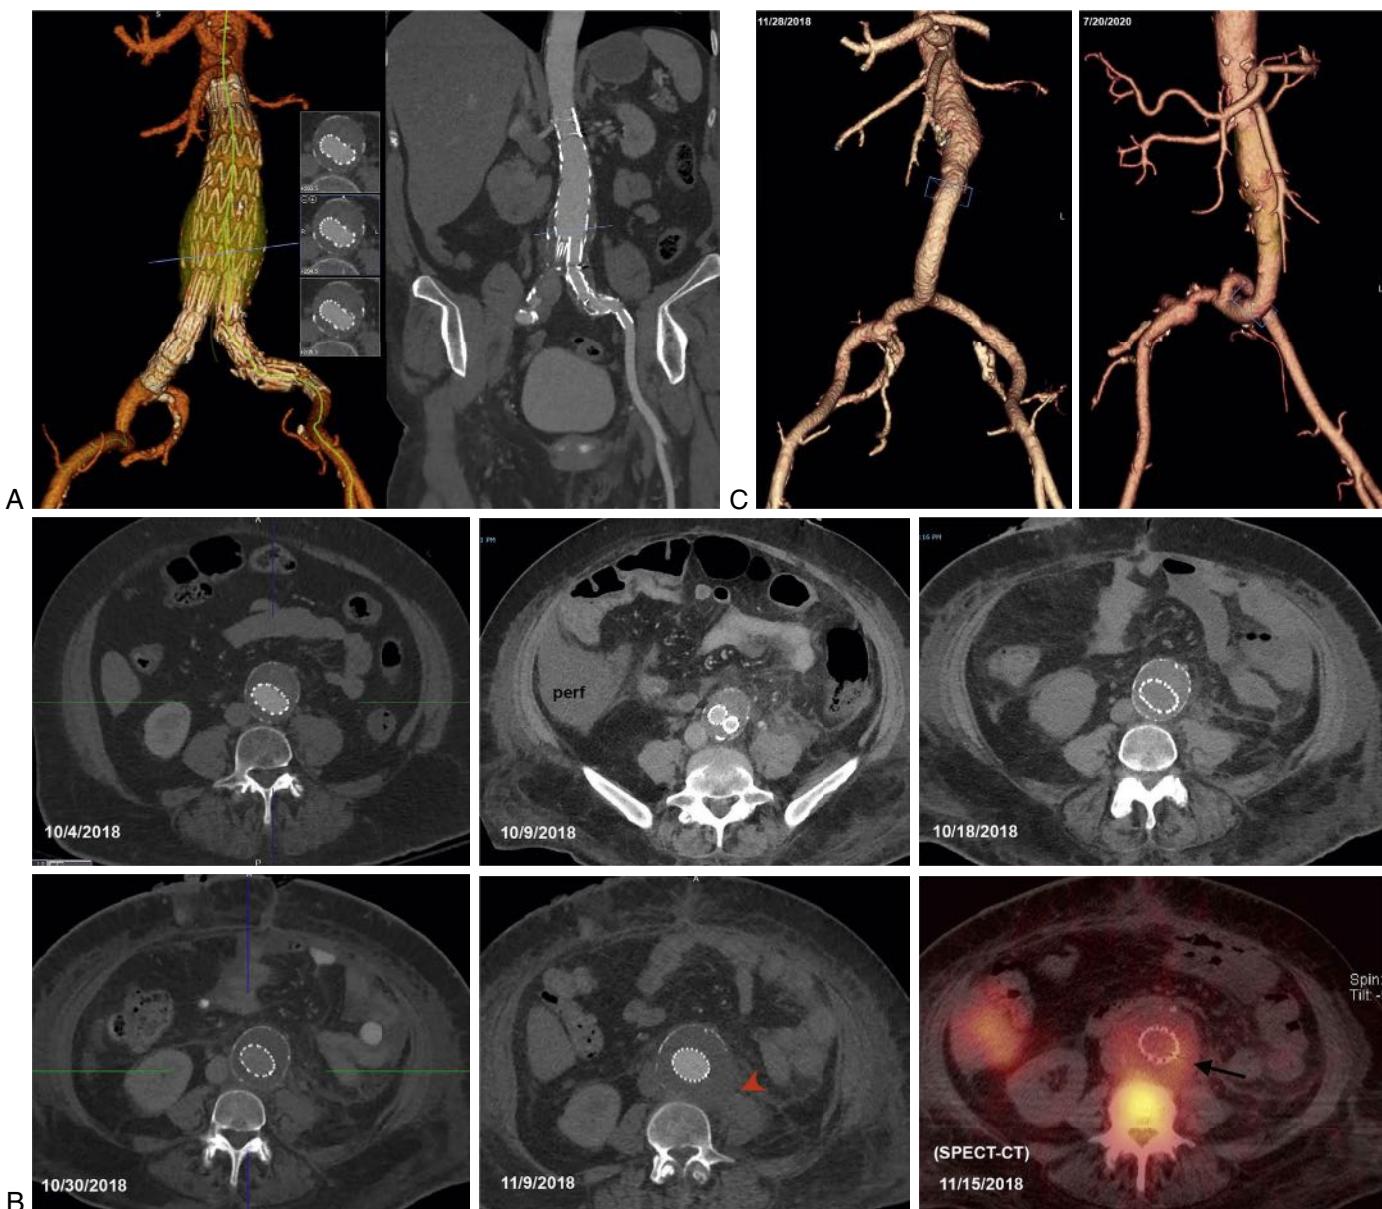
A 63-year-old female patient who underwent an EVAR for a 5.2-cm infrarenal AAA using a Zenith Flex device (Cook, Bloomington, IN). She had an ectatic left common iliac artery necessitating coverage of the hypogastric artery and extension into the external iliac artery. (A) CTA on postoperative day 1 after development of low abdominal pain. Endoscopic diagnosis of ischemic proctocolitis, initially managed conservatively until she developed perforation requiring hemicolectomy with colostomy. Her course was also complicated by *Clostridium difficile* colitis and bacteremia on multiple blood cultures. (B) Serial CT examinations demonstrating progressive sac enlargement, with periaortic fatty stranding evolving into a discrete periaortic phlegmon, eventually with loss of left posterolateral aortic wall integrity (red arrowhead). The last panel demonstrates increased isotopic uptake in the sac on a tagged-WBC scan using SPECT-CT fusion (black arrow). She was taken to the operating room 40 days after the initial EVAR, where she underwent complete explantation of the device (including the suprarenal fixation stent). Extensive debridement of all infected and necrotic tissue was performed. *In situ* reconstruction was performed using a cryopreserved allograft anastomosed distally to the right common iliac bifurcation and left external iliac artery. (C) Follow-up CTA, 2 years later, shows the reconstruction to be widely patent, with resolution of pelvic inflammation. Note the remodeling resulted in ventral tortuosity that has occurred with subsequent healing (compared to CTA performed 10 days after the repair).
